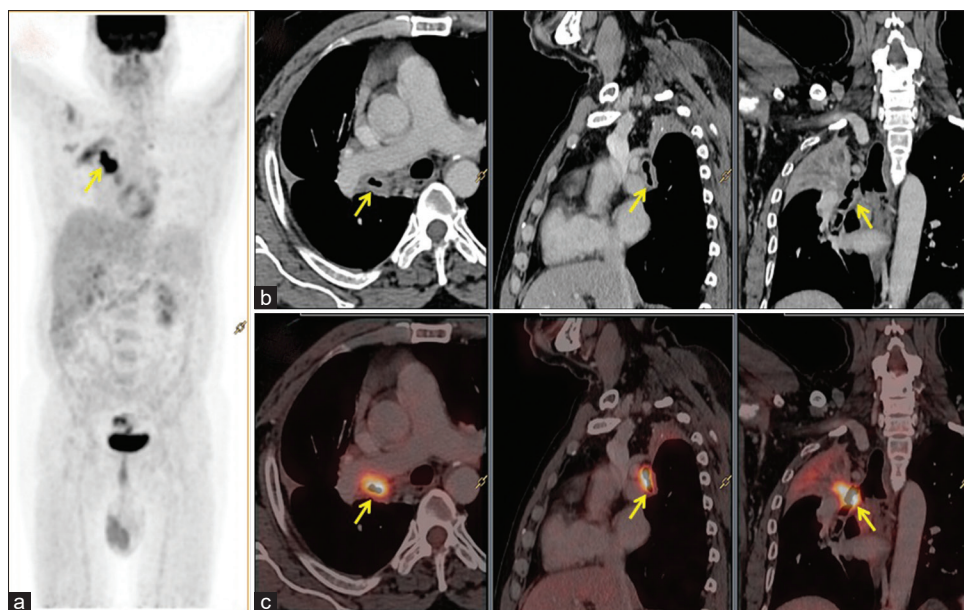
(a) MIP image of 18F-FDG PET shows focal area of FDG uptake in right hemithorax, (yellow arrow) (b) CT images showing continuous thickening in right bronchus (yellow arrow) in axial, sagittal, and coronal projections, respectively, (c) PET/CT fused images showing hypermetabolism along the right bronchus (yellow arrow) in axial, sagittal, and coronal projections, respectively. 18F-FDG PET: 18Fluorodeoxyglucose positron emission tomography, CT: Computed tomography, MIP: Maximum intensity projection
